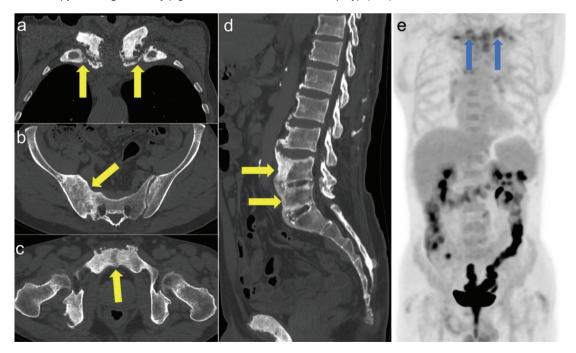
CT bone-window images demonstrating hypertrophic changes and osteosclerosis in the bilateral sternoclavicular joints (a, yellow arrow), right sacroiliac joint (b, yellow arrow), pubic symphysis (c, yellow arrow), and anterior vertebral segments (d, yellow arrow). Maximum-intensity projection PET/CT image showing increased radiotracer uptake in both sternoclavicular joints and the colorectal region (e, blue arrow)
